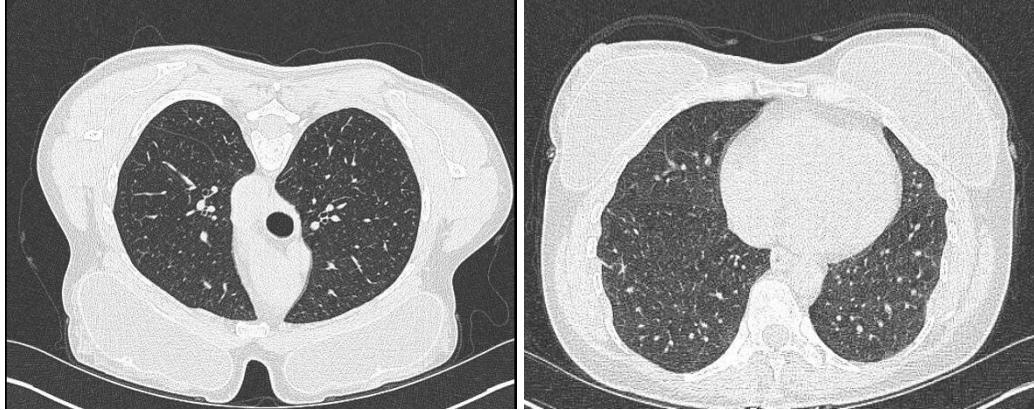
CT scan of the chest, axial view, with resolution of bilateral opacities after five months of glucocorticoid therapy.
